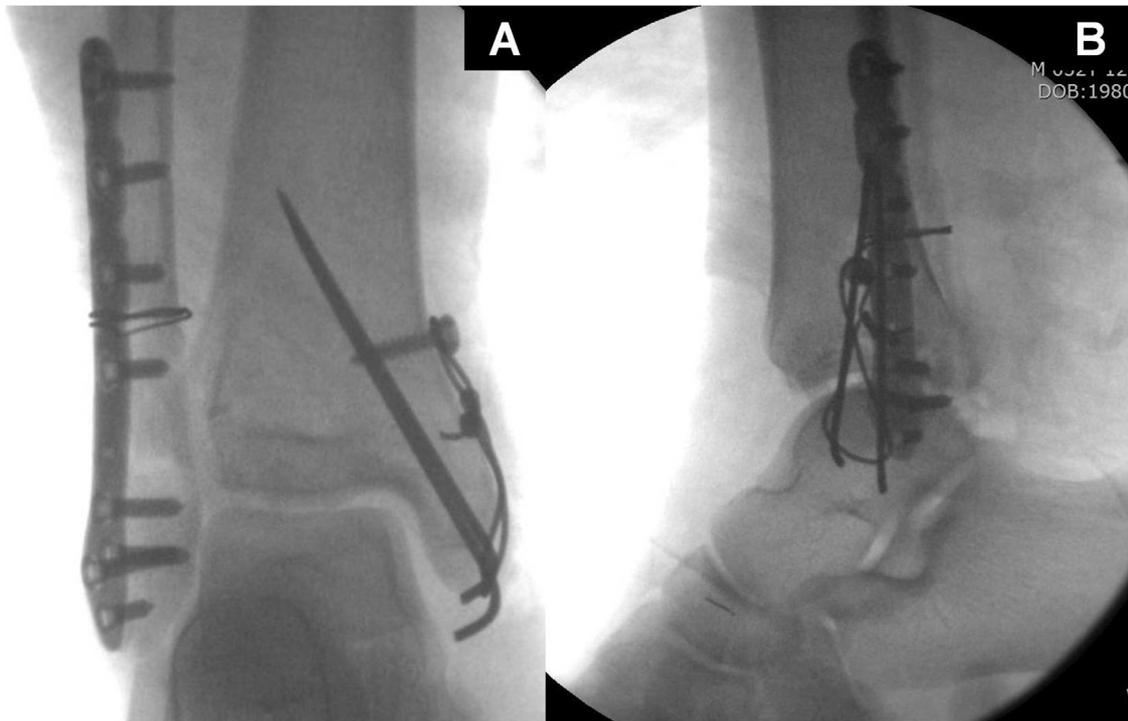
(A–B) Postoperative radiographs show the normal alignment of the ankle mortise following open reduction and internal fixation.
